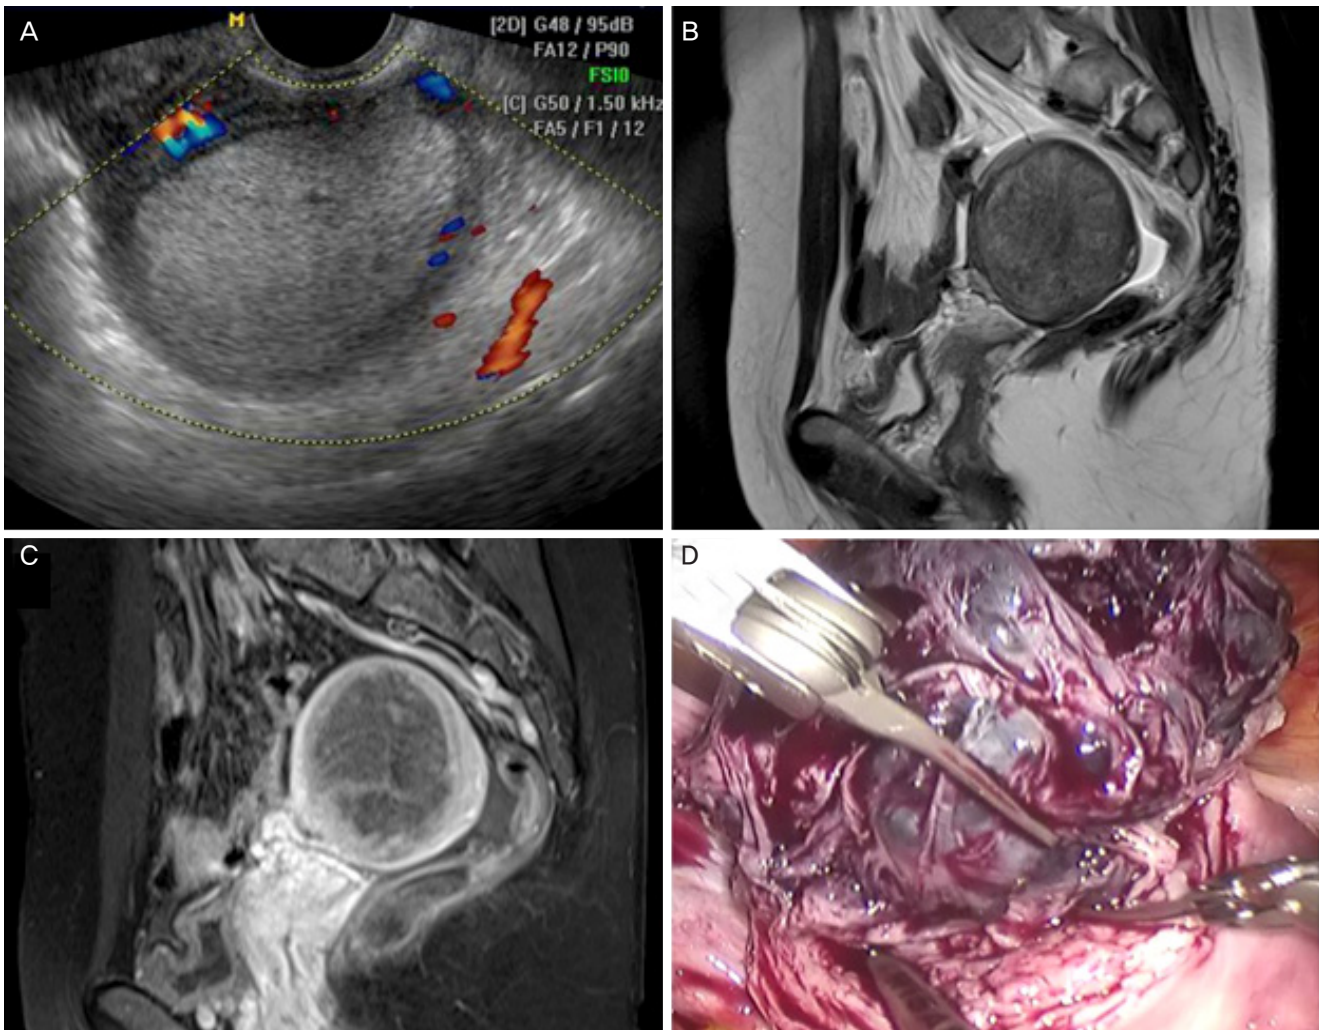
(A) Transvaginal ultrasonography showing a 4.5 cm sized hyperechoic mass with vascular structures around the mass. (B) Sagittal view on pelvic magnetic resonance image showing 5.1 cm sized heterogeneous, intermediate to high signal intensity in T2-weighted image and (C) poor enhancement in T1-weighted post-gadolinium image. (D) Intra-operative findings showing about 5 cm sized, blood-filled multicystic tumor mass in the myometrium.
